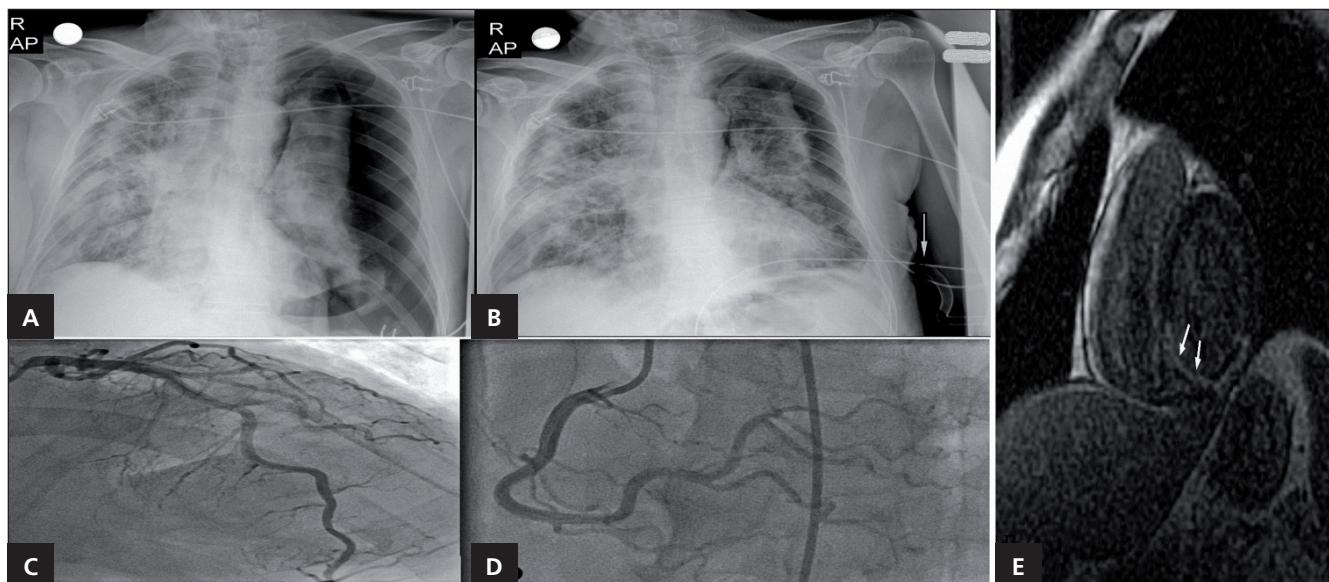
Chest radiography shows (A) massive pneumothorax of the left lung and frequent consolidations of right lung. (B) Re-expansion of the left lung with the insertion of a drain (white arrow). (C, D) Coronary angiography was normal. (E) Cardiac magnetic resonance imaging (MRI) showed inferior wall scar.
